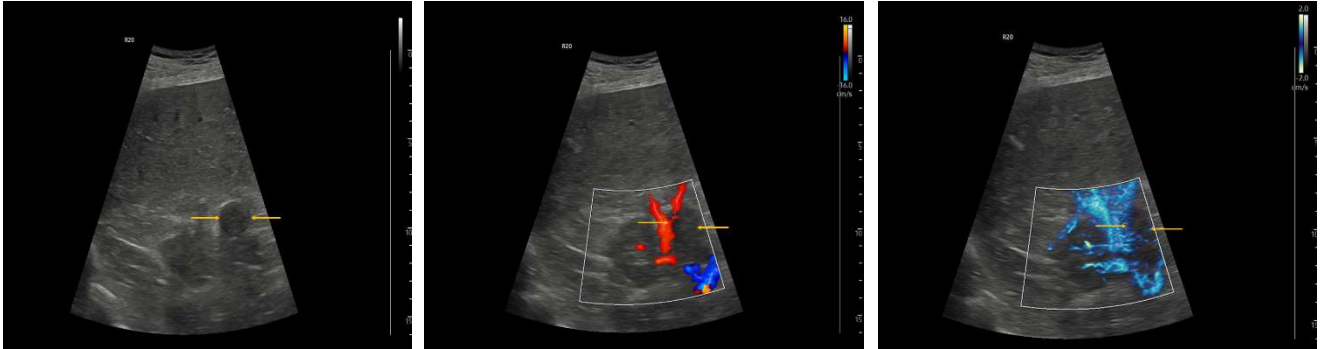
67-year-old female patient with a nearly hypoechoic lesion (yellow arrows), in the baseline CT examination a hemorrhage cyst of the right kidney was described.
